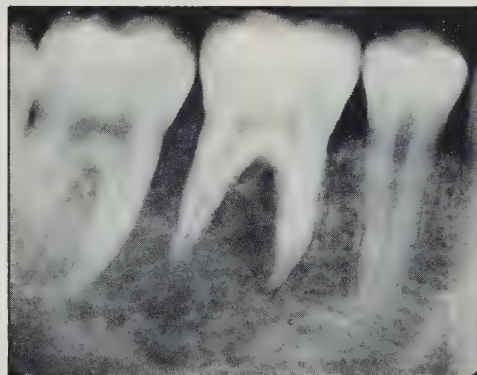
Periapical radiograph made at initial dental consult. Note the diffuse irregular radiolucency and loss of lamina dura around the roots of 46 with radicular resorption.
